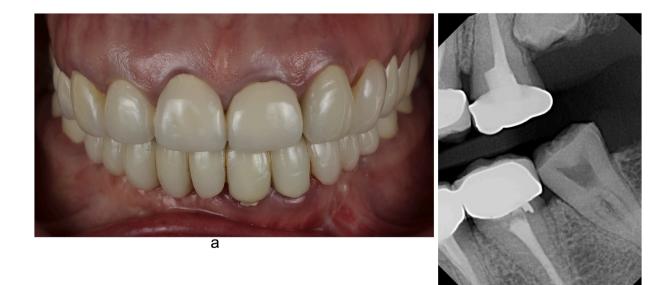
A 53-year old patient with hypomaturation-hypoplastic with taurodontism (type 4) amelogenesis imperfecta. Genetic testing revealed a pathogenic variant in the *DLX3* gene, confirming autosomal dominant amelogenesis imperfecta type IV and autosomal dominant tricho-dento-osseous (TDO) syndrome. (a) Intra-oral view. Previously completed full mouth rehabilitation with failing restorations noted. (b) Radiograph exhibiting a decrease in enamel thickness on unerupted #16.
